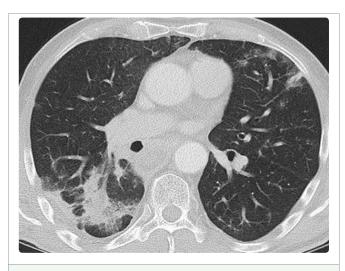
Follow up CT scan one year after tumour debulking and 10 months after radiation therapy: significant decrease in tumour size and pulmonal infiltrates in the right lower lobe and in the lingula, compatible with postradiogenic changes due to fibrosis.
